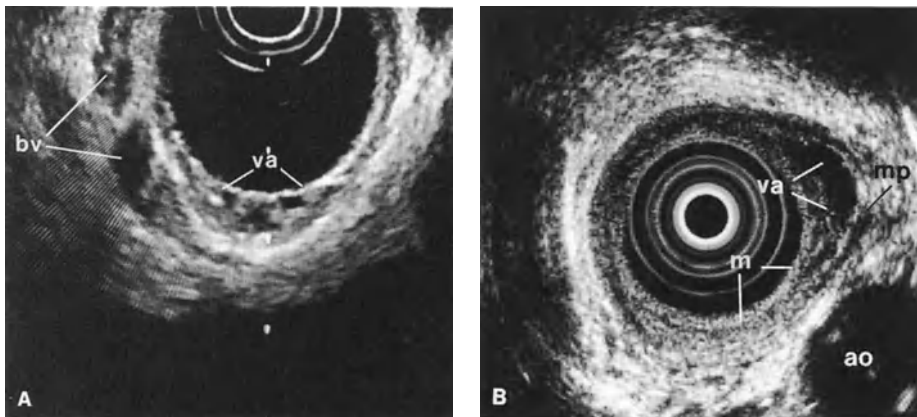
A, B. Endoscopic sonograms. A Ellipsoid anechoic structures (*va*) in the submucosal layer compatible with esophageal varices, together with periesophageal collateral veins. *bv*, blood vessel. B Ellipsoid anechoic structure (*va*) in the submucosal layer not penetrating the muscularis propria (*mp*). *m*, mucosa; *ao*, aorta
